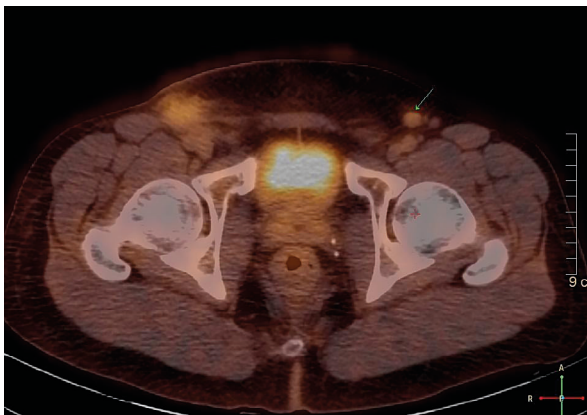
A patient with cutaneous melanoma of the trunk after excision of the primary tumor and right inguinal lymph node dissection, pT4b pN1b cM0. The patient was referred for an 18F-FDG PET/CT staging. There was a non-significant, but suspicious inguinal lymph node on the left, with no fatty center, with round shape, and metabolic activity slightly higher than the background. The patient was referred for an ultrasonographic exam and afterward for an excision
